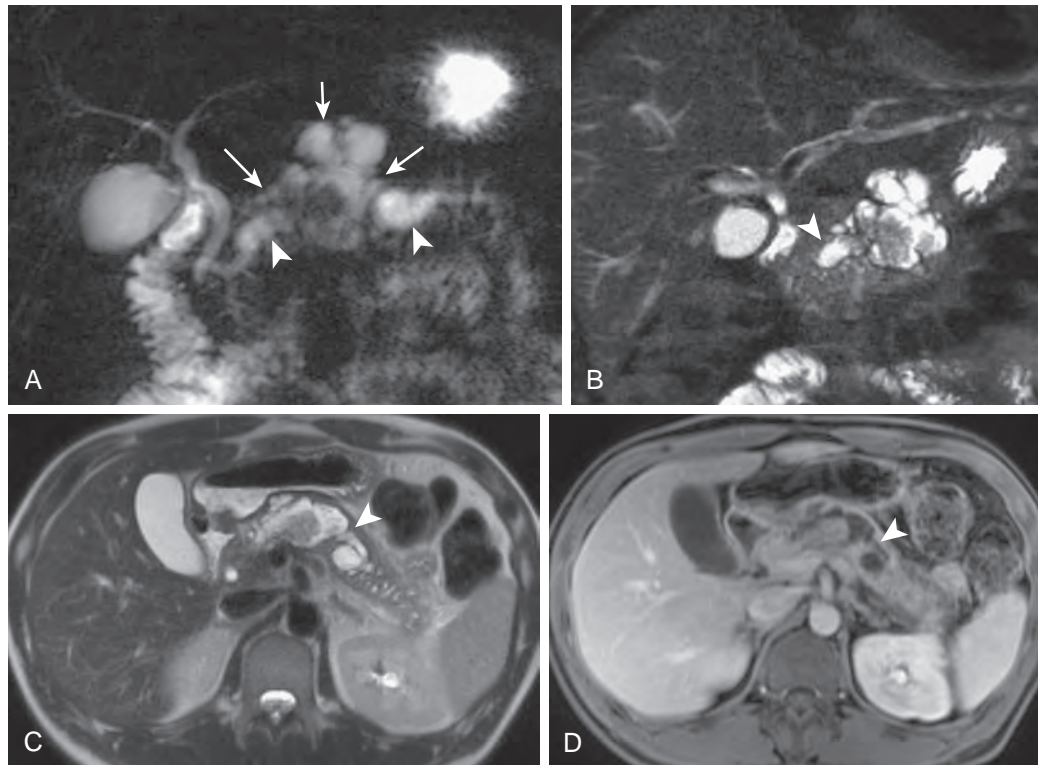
Malignant intraductal papillary mucinous neoplasm of the pancreas, main duct type. A. Coronal thick-slab MRCP reveals a large cystic lesion (arrows) that contains nodular filling defects and that communicates with the main pancreatic duct in the pancreatic body (arrowheads). Incidental note is made of pancreas divisum as evidenced by the horizontal orientation of the main pancreatic duct in the pancreatic head. B-D. Coronal oblique thin-slab MRCP, axial HASTE image, and axial T1-weighted, fat-suppressed, contrast-enhanced abdominal MRI show in detail the lobulated cystic mass and the nodular filling defects as well as the dilated pancreatic duct (arrowhead) from which the mass arises.
